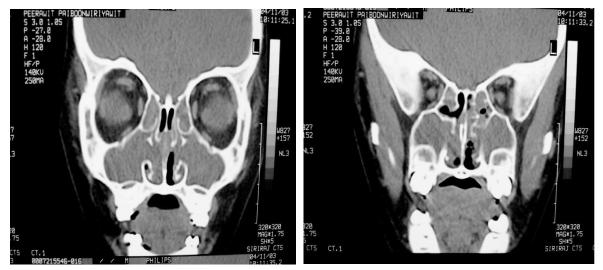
The computerized tomography (CT) scan of paranasal sinus (PNS) of patient No. 1 showed soft tissue mass, occupying nasal cavity, ethmoid, sphenoid, frontal and maxillary sinuses. There was destruction of nasal turbinate and osteomeatal complex (OMC)
